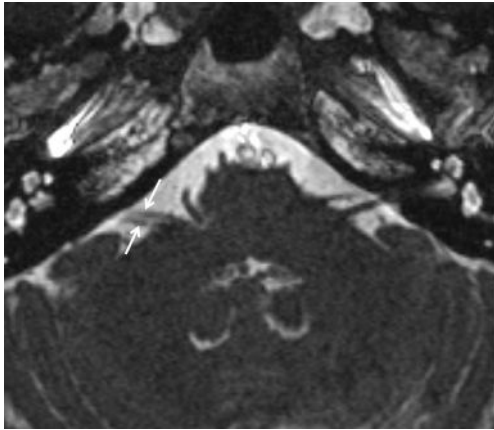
A 49-year-old woman with hypoplasia of the right 7th/8th cranial nerves. Heavily T2-weighted MRI image with 1-mm section thickness of the posterior fossa shows the narrow right 7th/8th cranial nerves (arrows). See the normal 7th/8th cranial nerves on the contralateral side. There was no abnormality in the 6th cranial nerve.
